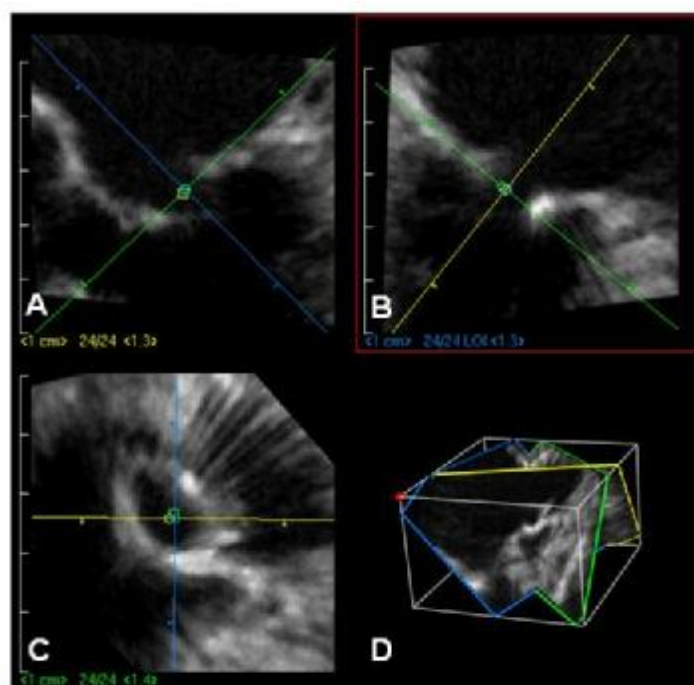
Mitral valve area measurement using anyplane echocardiography. Two long-axis cut planes perpendicular to each other (A and B). By guidance of line of intersection, optimal short-axis cut plane was selected (C). 3D data set and spatial alignment of 3D cut planes (D).
